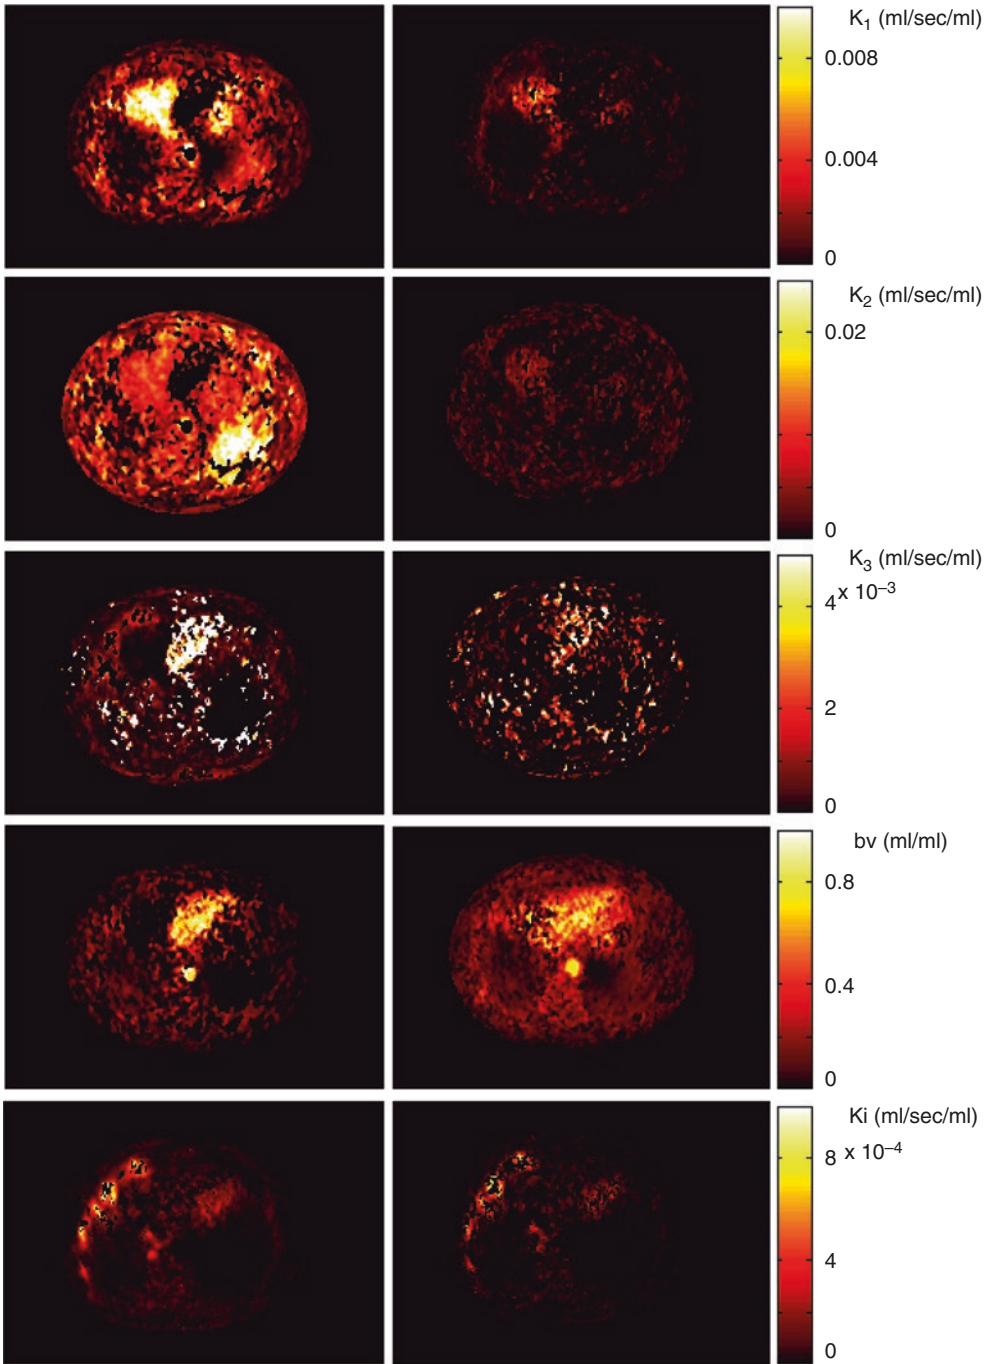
An abdominal dynamic FDG-PET/CT kinetic analysis. The figure shows the three-compartment parameter map (K_1, k_2, k_3) model assuming irreversible kinetics ($k_4=0$), blood volume component ($bv=K_1/k_2$), and K_{FDG}
